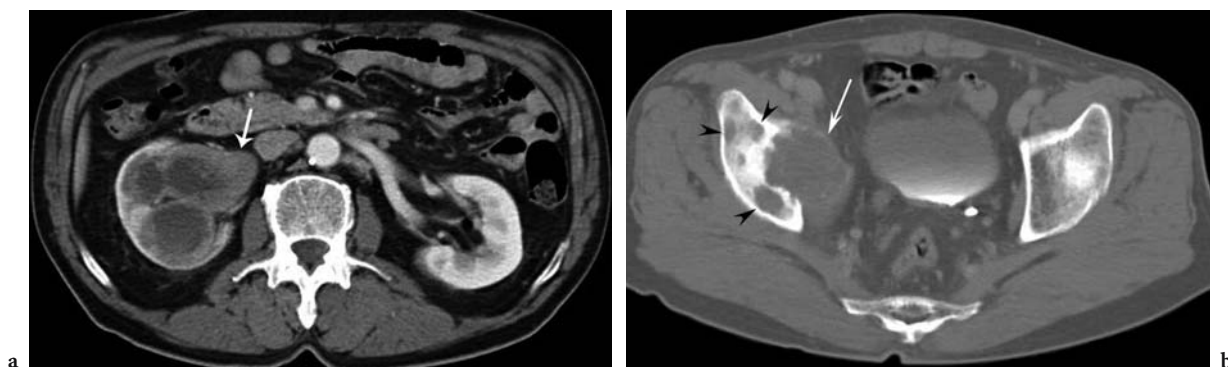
Invasive transitional cell carcinoma with bone metastasis in a 64-year-old man. a Axial contrast-enhanced CT scan obtained during the nephrographic phase shows an ill-defined hypodense tumor (*arrow*) in the dilated renal pelvis growing into the renal parenchyma while preserving the reniform outline of the right kidney. b Axial CT scan at the level of the sacrum shows a large expansile mass (*arrow*) with multifocal bone destruction in the right iliac bone (*arrowheads*).
